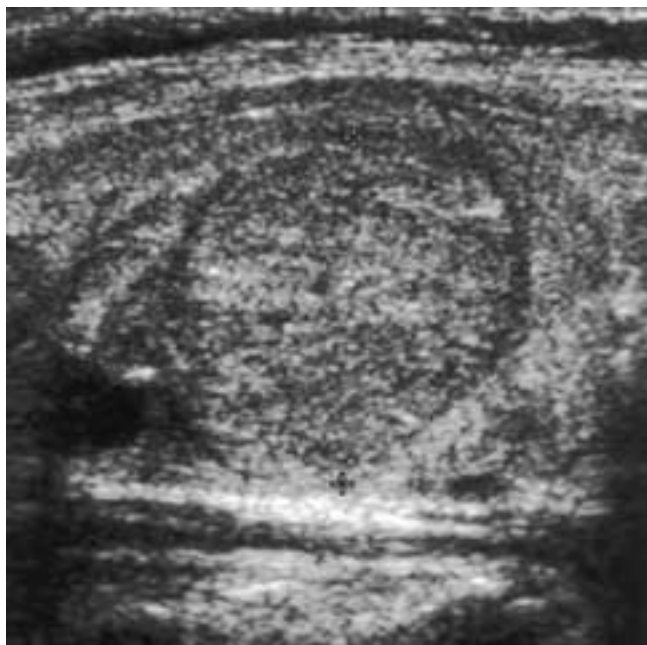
Ultrasonography of the thyroid gland in a patient with a palpable nodule. Note the homogeneous, echogenic nodule with a “sonolucent halo” suggestive of a benign thyroid lesion. At pathology this was shown to be a follicular adenoma. (Courtesy of Dr. Jill Langer, Department of Radiology, Ultrasound Division, University of Pennsylvania Medical Center.)
